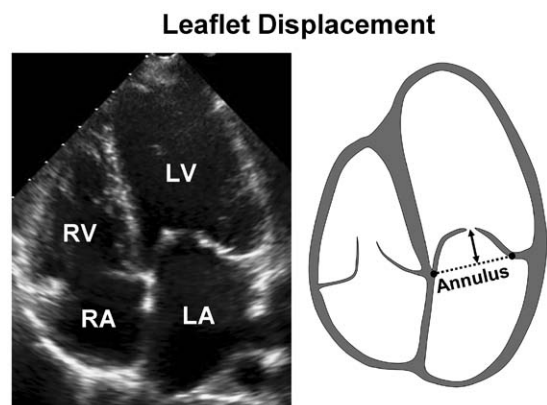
Echocardiographic apical 4-chamber view showing maximum apical displacement of the leaflets relative to the mitral annulus. LA indicates left atrium; LV, left ventricle; RA, right atrium; and RV, right ventricle.
